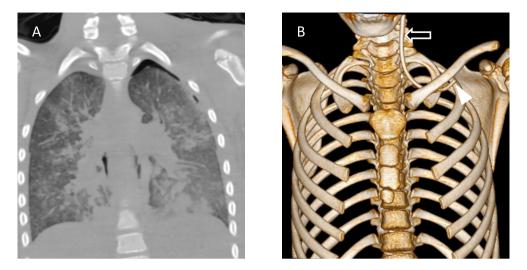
A 10-year-old boy who died in the hospital after a fall. a Postmortem CT shows a small pneumothorax, which was not found at autopsy. There is diffuse airway consolidation in keeping with postmortem pulmonary edema. Figure 10b. Surface-shaded rendering of the thorax shows an incorrectly positioned left subclavian line with the tip of the line in the jugular vein (arrow). The line was cut and the distal end (arrowhead) was buried subcutaneously.
